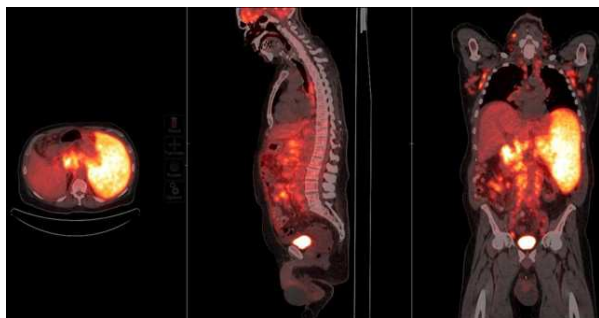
Pre-treatment PET/CT scan showing extensive FDG-avid tumor featuring mantle cell lymphoma with diffuse nodal involvement and massive splenomegaly.
